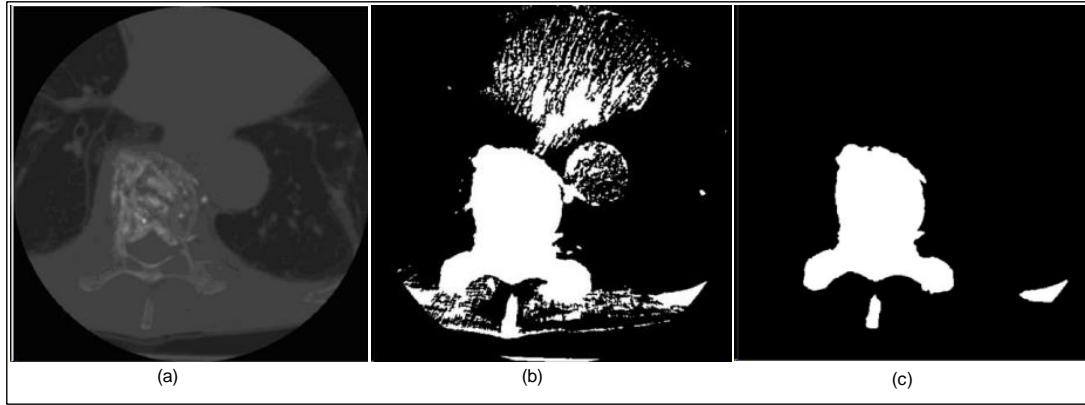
Applying thresholding on CT image: a) original CT images b) initial segmentation. (d) Bone region after iterative adaptive thresholding [45].
